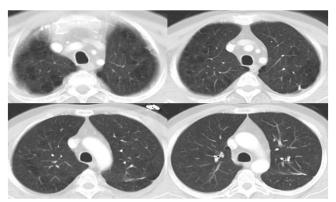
Post-treatment follow-up thorax computed tomography; bilateral nodular lesions completely regressed
